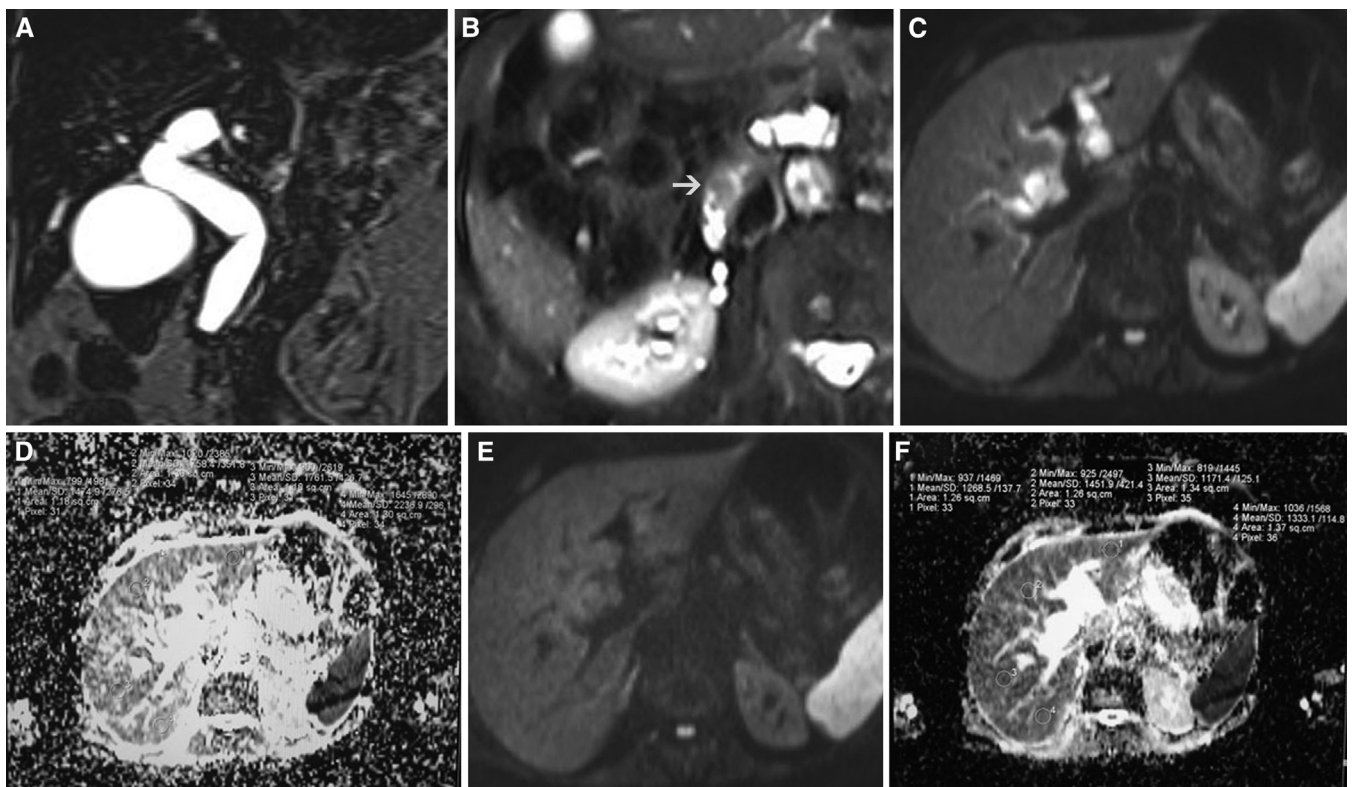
Ampullary carcinoma in a 52-year-old man. (A) Magnetic resonance cholangiopancreatography shows dilatation of gallbladder with abrupt cutoff of common bile duct. (B) Axial T2-weighted magnetic resonance image shows low-intensity lesion at the ampullary region (arrow). (C) Diffusion-weighted image of the liver with a b-factor of 200 s/mm^2 , (D) the corresponding ADC image of the liver. The regions of interest are in the 4 segments of the liver. Minimum, maximum, and mean ADC values and standard deviations are seen. (E) Diffusion-weighted image of the liver with a b-factor of 600 s/mm^2 , (F) the corresponding apparent diffusion coefficient (ADC) image of the liver. The regions of interest are in the 4 segments of the liver. Minimum, maximum and mean ADC values and standard deviations are seen.
